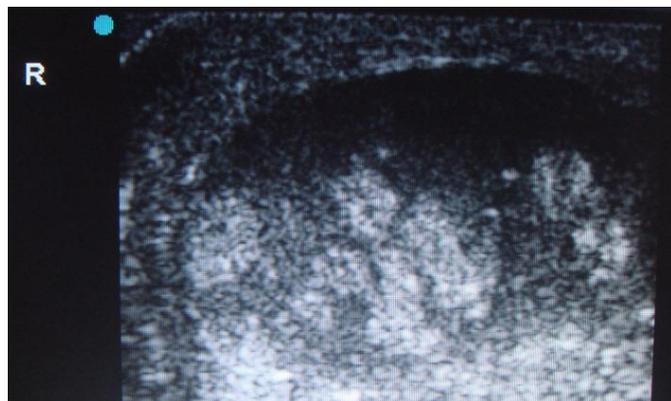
Grayscale ultrasound (longitudinal plane, mid testis) of the right testis in a case of subacute (“missed”) torsion demonstrating hyperechoic foci consistent with necrosis. The patient had ongoing right scrotal pain.
